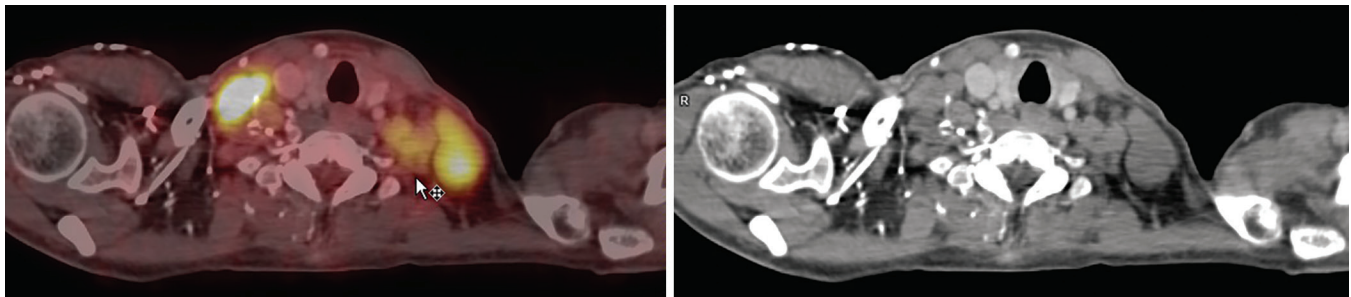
PET CT showing increased FDG of homogeneously enhancing enlarged bilateral cervical and bilateral supraclavicular lymph nodes (on the left measuring 3.6 × 2.4 cm, standardized uptake value max 5.9). Biopsy taken from avid supraclavicular node under ultrasound guidance
